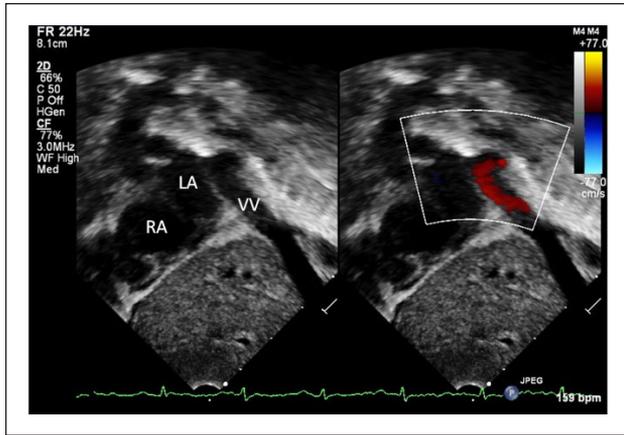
Transthoracic echocardiogram from the subxiphoid short-axis view showing the dilated vertical vein coursing caudally through the diaphragm and into the liver parenchyma. Color Doppler shows caudal direction of pulmonary venous flow toward the diaphragm. Abbreviations: VV, vertical vein; LA, left atrium; RA, right atrium.
